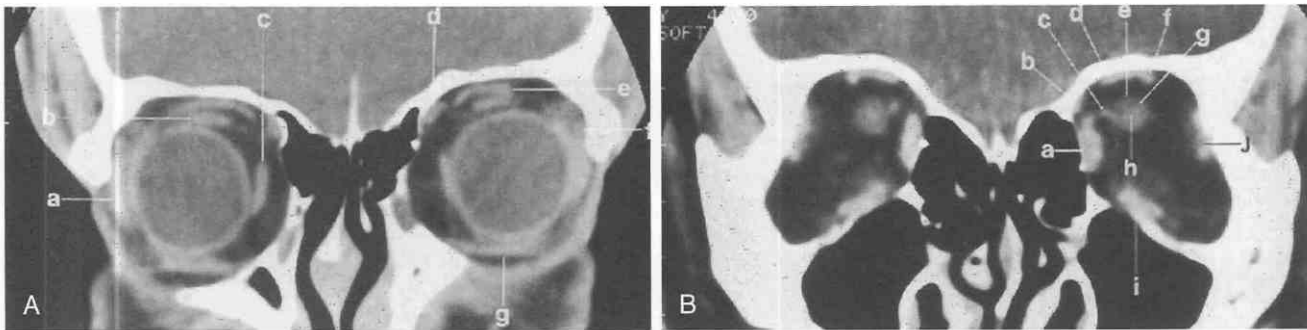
A, Coronal CT scan: normal anatomy. Lateral rectus (a), superior rectus (b), medial rectus (c), superior oblique (d), levator palpebrae superioris (e), lacrimal gland (f), inferior oblique (g). B, Medial rectus (a), superior oblique (b), ophthalmic artery (c), superior rectus/levator palpebrae superioris complex (d), dural sheath (e), superior ophthalmic vein (f), subarachnoid space (g), optic nerve (h), inferior rectus (i), lateral rectus (j).
